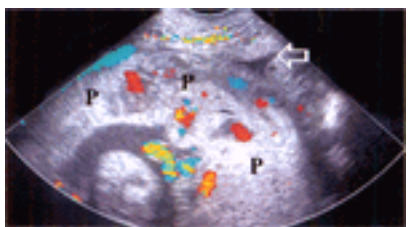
Transvaginal ultrasonogram of a placenta previa. The placenta (*P*) covers the internal os. The tip of the transvaginal probe is in the anterior fornix. (This figure is printed in black and white as [Figure 8.27](#))
